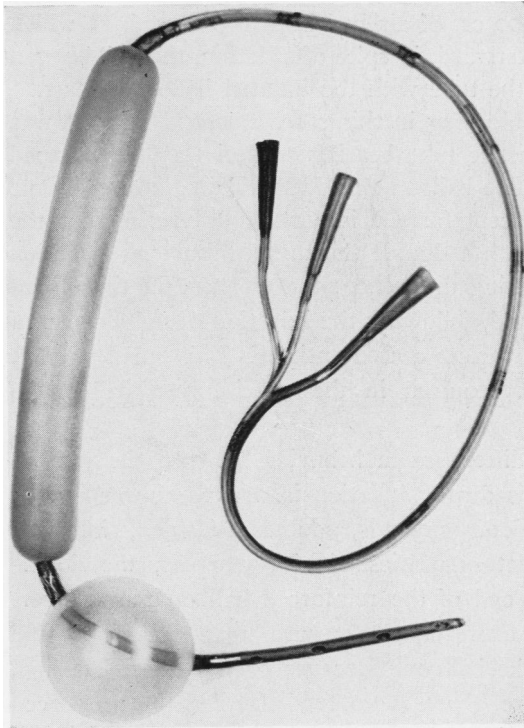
A photograph of a nasogastric tube-balloon assembly for the emergency control of hemorrhage from esophageal varices. Note the generous size of the tube for gastric suction. Observe that the distal one-third of the sausage-shaped esophageal balloon is more shaded, indicating a greater thickness of rubber. A metal roentgen ray marker is incorporated in the wall of the tube between the balloons.
